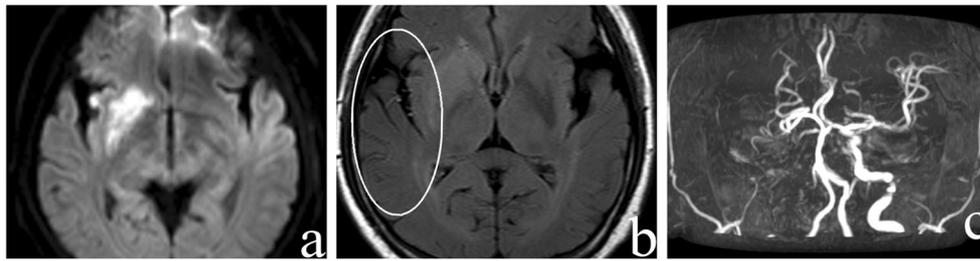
A patient with persistent left hemiparesis and dysarthria. DWI showing regional hyperintensity in right basal ganglion (a). FLAIR imaging showing FVH in the region of the right MCA (b) and MRA
